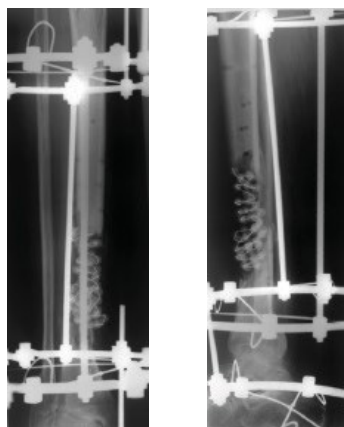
8-weeks postoperative radiographs demonstrating infection interventions
